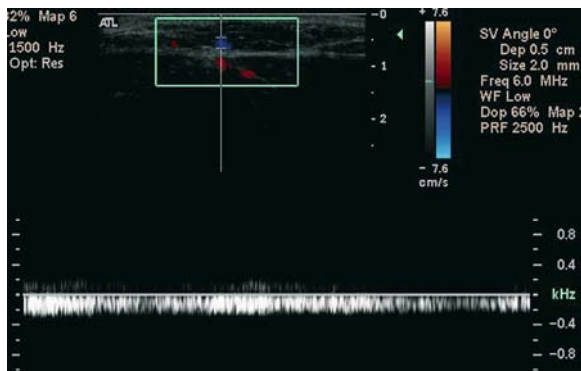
Doppler US in another patient with a superficial venous malformation shows typical venous flow on pulsed Doppler
